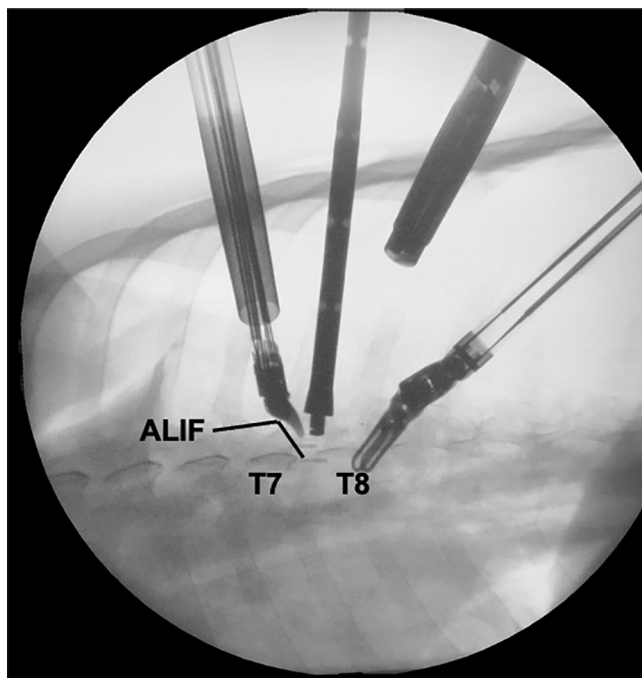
Control with the C arm X-Ray machine; The level and cage position is control by C-arm. The cage is observed in the T7-8 disc level.
